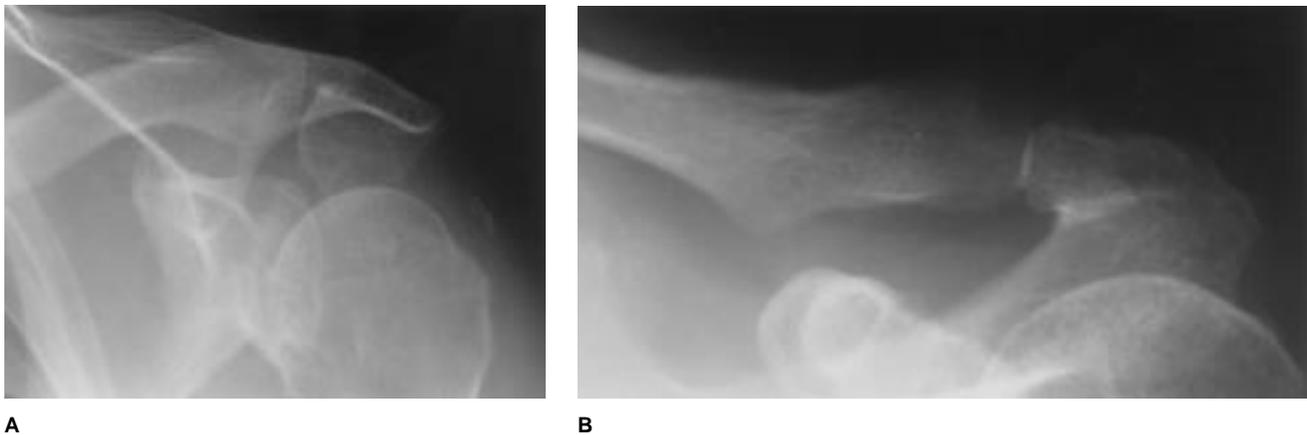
The 30-degree caudal-tilt radiograph (A) and the Zanca view (B) are useful adjuncts to the supraspinatus outlet and axillary views when evaluating patients with continued pain after rotator cuff surgery.
